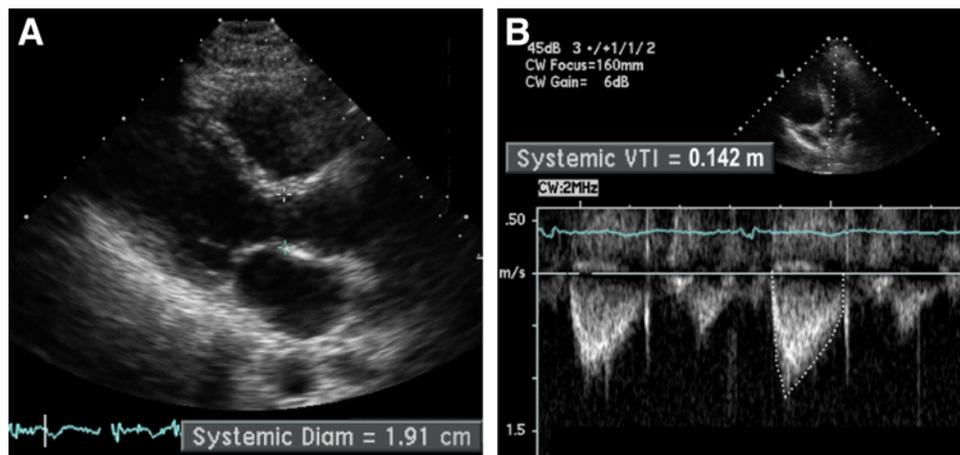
Quantification of shunt flow ($Q_p:Q_s$) requires measurement (*see* Anatomic and Echocardiographic Overview section). Systemic flow calculation requires measurement of left ventricular outflow tract diameter (A) and the velocity time integral (VTI) by PW Doppler (B).
